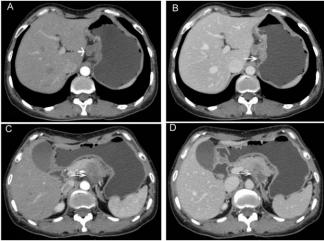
A 47 yr old women with mixed hepatoid carcinoma. A, B Axial contrast enhanced CT scan image showing eccentric wall thickening (white arrow) in body of stomach, with hypoattenuating, heterogenous enhancement in arterial and portal venous phase respectively. Spread of tumor to adjacent pancreas (white arrow) visible hypoattenuating as heterogeneous mass in pancreas with indistinct margin in arterial and portal venous phase respectively (C, D). The fat plane between the pancreas and stomach appears to be obliterated.
